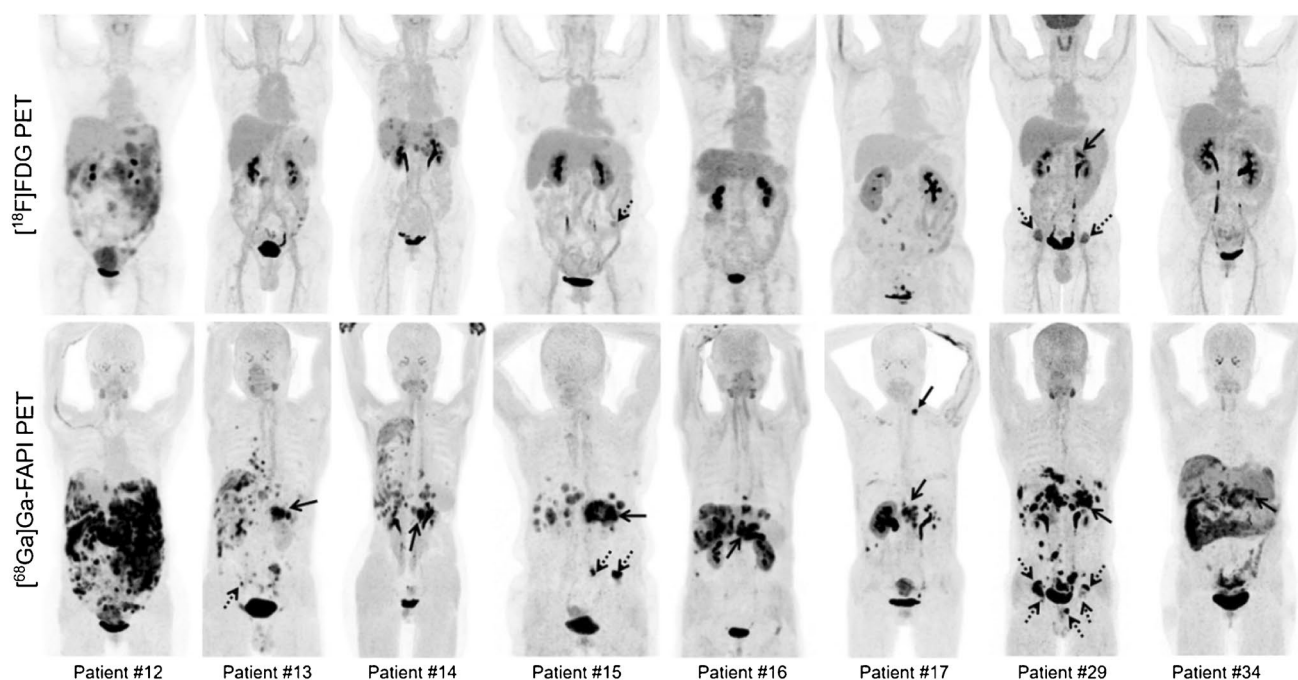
Eight representative patients with pancreatic cancer underwent [^{18}F]-fluorodeoxyglucose (^{18}F FDG) and [^{68}Ga]-Ga-labeled fibroblast activation protein inhibitor (^{68}Ga]-Ga-FAPI) positron emission tomography/computed tomography (PET/CT) imaging. [^{68}Ga]-Ga-FAPI PET/CT outperformed [^{18}F]-FDG PET/CT in detecting primary tumors (patient nos.13, 14, 15, 16, 17, 29, 34; indicated with solid
